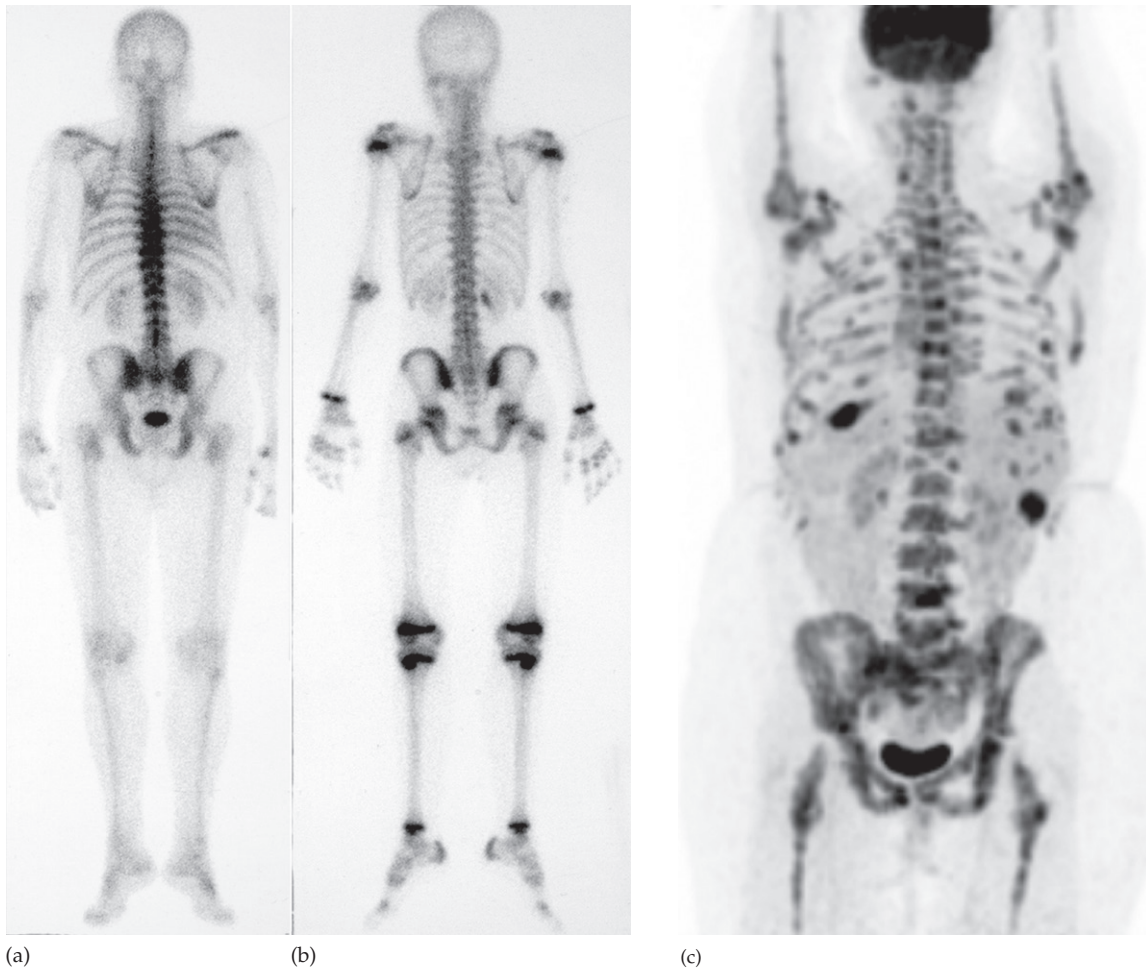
(a,b) Normal radionuclide bone scan. (a) Adult. Note the radionuclide in the bladder. (b) Child. Note the bands of increased uptake in the epiphyseal plates where bone growth is occurring. (c) FDG-PET/CT demonstrates multiple, metabolically active bone metastases in a patient with breast cancer.
